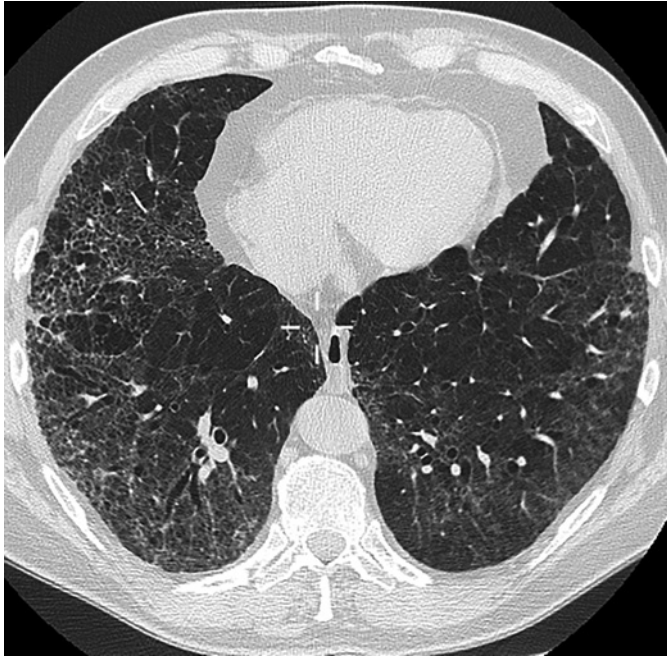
Chest CT follow-up 2 years after COVID infection. Important fibrotic lung changes with diffuse fibrotic ground glass associated with traction bronchiectasis, volume loss, and fibrotic reticulation.
